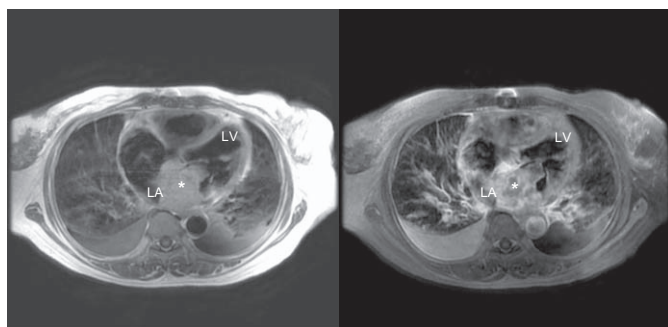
The mass (*) in the left atrium showed high signal intensity on T1-weighted magnetic resonance images. The mass extended to the right atrium, coronary sinus, and inferior vena cava. LA=left atrium, LV=left ventricle.
